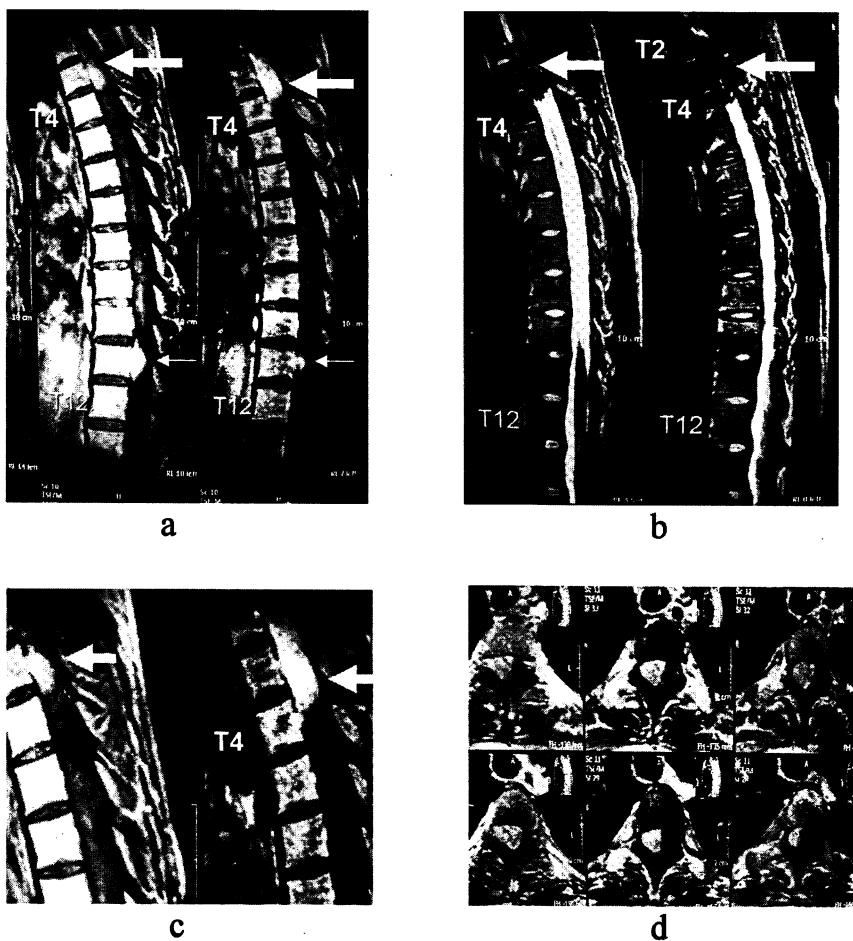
Sagittal view of MRI T1WI with gadolinium (a, c), T2WI image (b) and axial view of T2-4 spine (d) revealed an extradural, slightly hypersignal intensity mass $1.5 \times 1.3 \times 5.1$ cm. at right side of T2-T4 levels (large arrow) compressed and displaced spinal cord to the left and at T11 level (small arrow).
